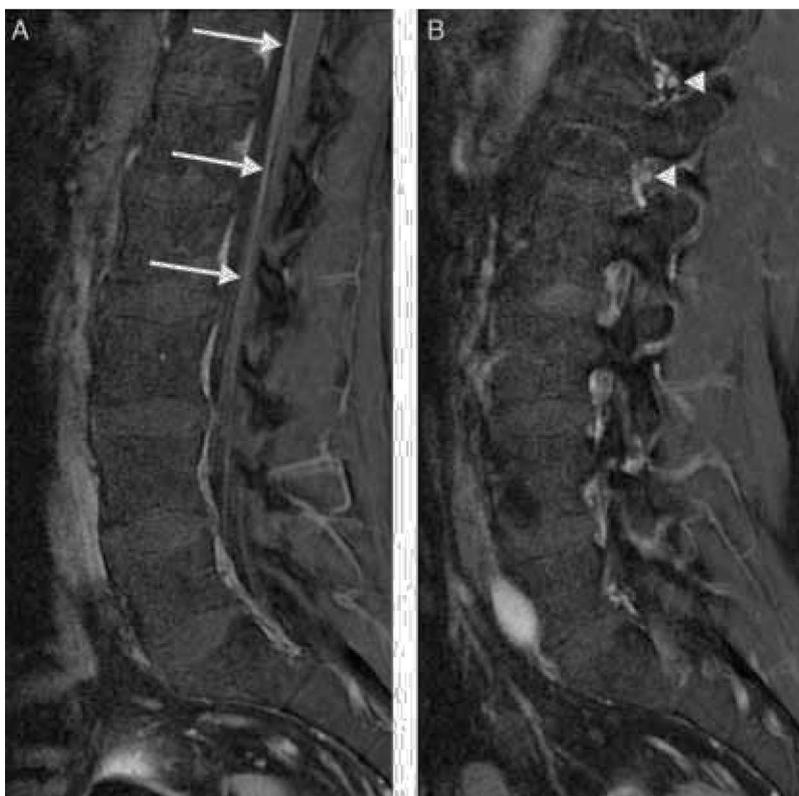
Fat-suppressed T1-weighted MR images with gadolinium contrast. (A) Marked enhancement of the cauda equina roots showing thickening (arrows). (B) MRI of the right intervertebral foramina showing enhancement of L1 and L2 (arrowheads).
